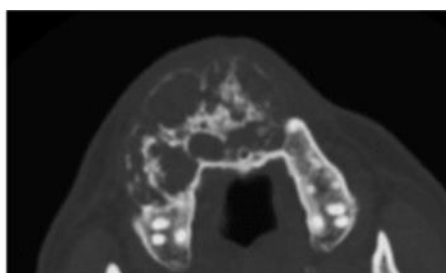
The 3D CBCT image reveals that the lesion has spread to the left side of the mandible. An axial view of the buccolingual cortical plate reveals expansion and perforation on the same side. The coronal section reveals diffuse, multilocular lesions with a soap-bubble-like appearance. Additionally, buccolingual expansion is noted. (Source: International Journal of Research & Review)<sup>14</sup>
